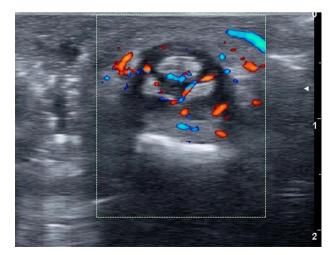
Ultrasound transversal view demonstrates tenosynovitis with power Doppler signal inside the tendon sheath and the surroundings.
